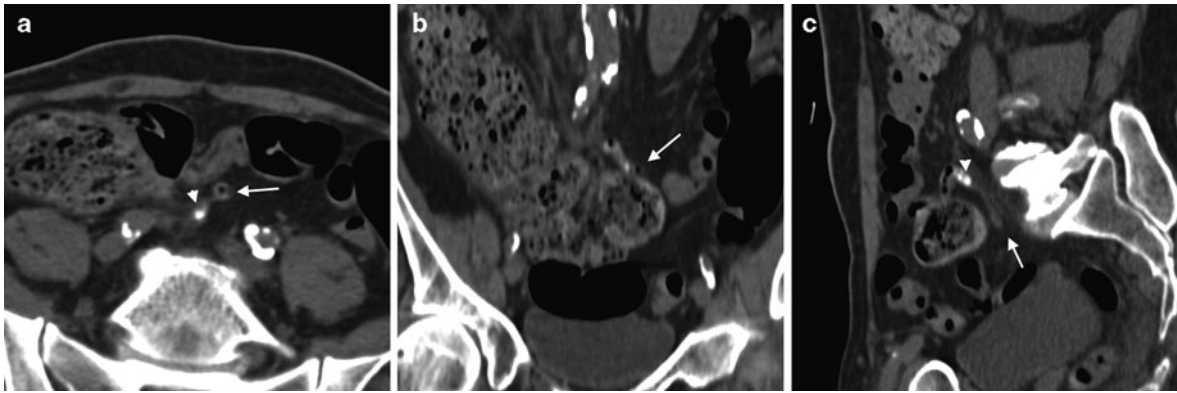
a, b, c Centro-abdominal normal appendix (*arrow*), containing an appendicolith (*arrowhead*), located in the medio-sagittal plane and anterior to the aortic bifurcation, seen on axial (a), coronal (b), and sagittal CT reformations (c)
